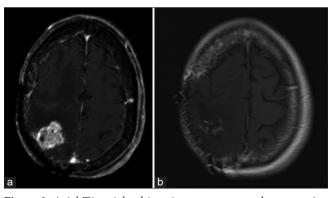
Axial T1-weighted imaging post contrast demonstrating (a) focal post-surgical changes from resection twelve years prior and an enhancing cortical lesion within the right parietal lobe concerning for recurrence. (b) immediate post-surgical changes of the right frontoparietal craniotomy for first recurrence with peripheral residual enhancement in resection cavity and mild enhancement in the superior aspect of the frontal lobe.
